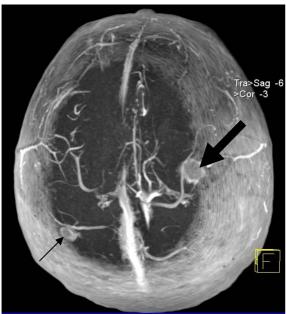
MRI exam – angiography 3D reconstruction:
